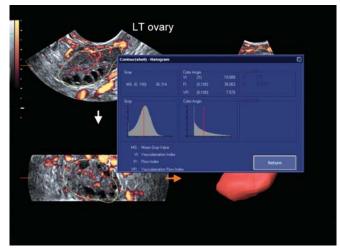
3D power Doppler volume histogram of ovary
